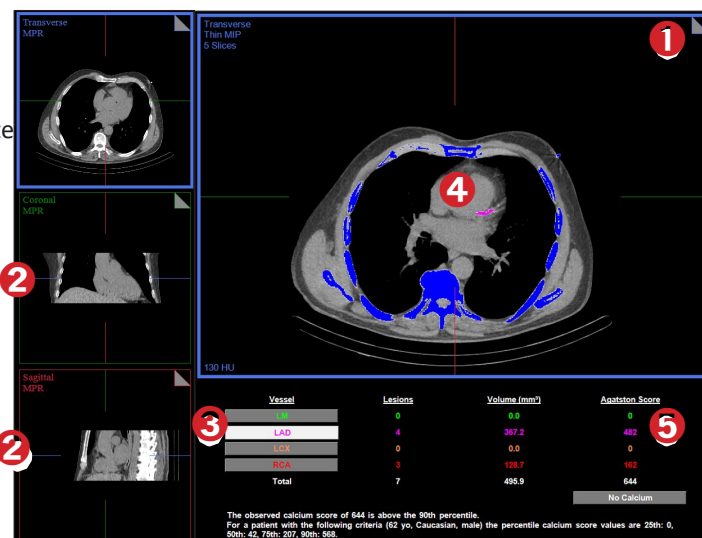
CT Volume with Region-growing Technique
